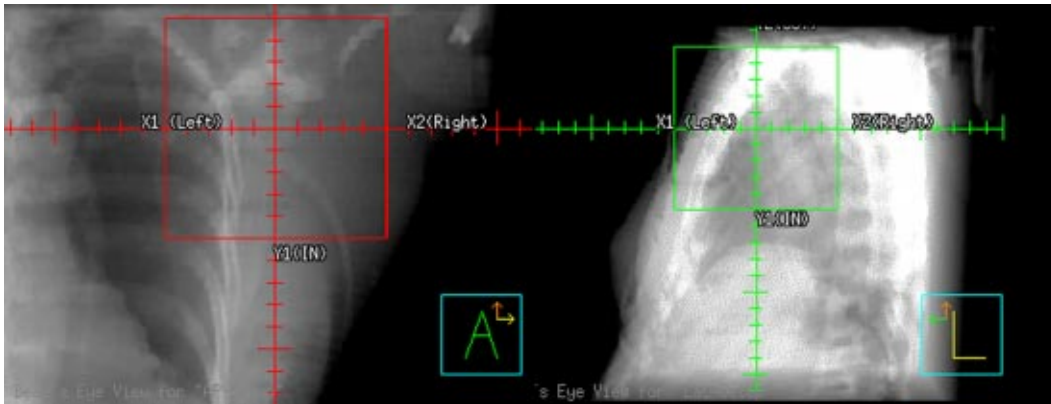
(Color) AP and left lateral digitally reconstructed radiographs for setup verification of the treatment isocenter (true beam isocenter).
